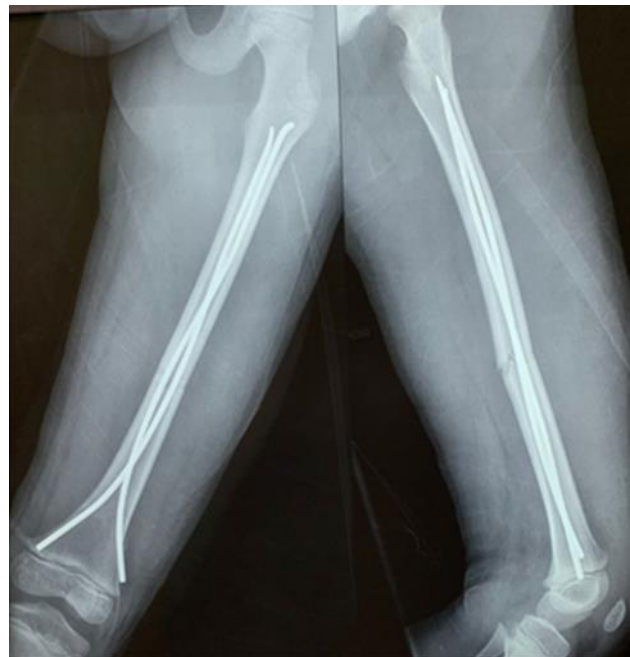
Immediate Post-Operative X-Ray Images of Left Femur (Anteroposterior and Lateral View)
